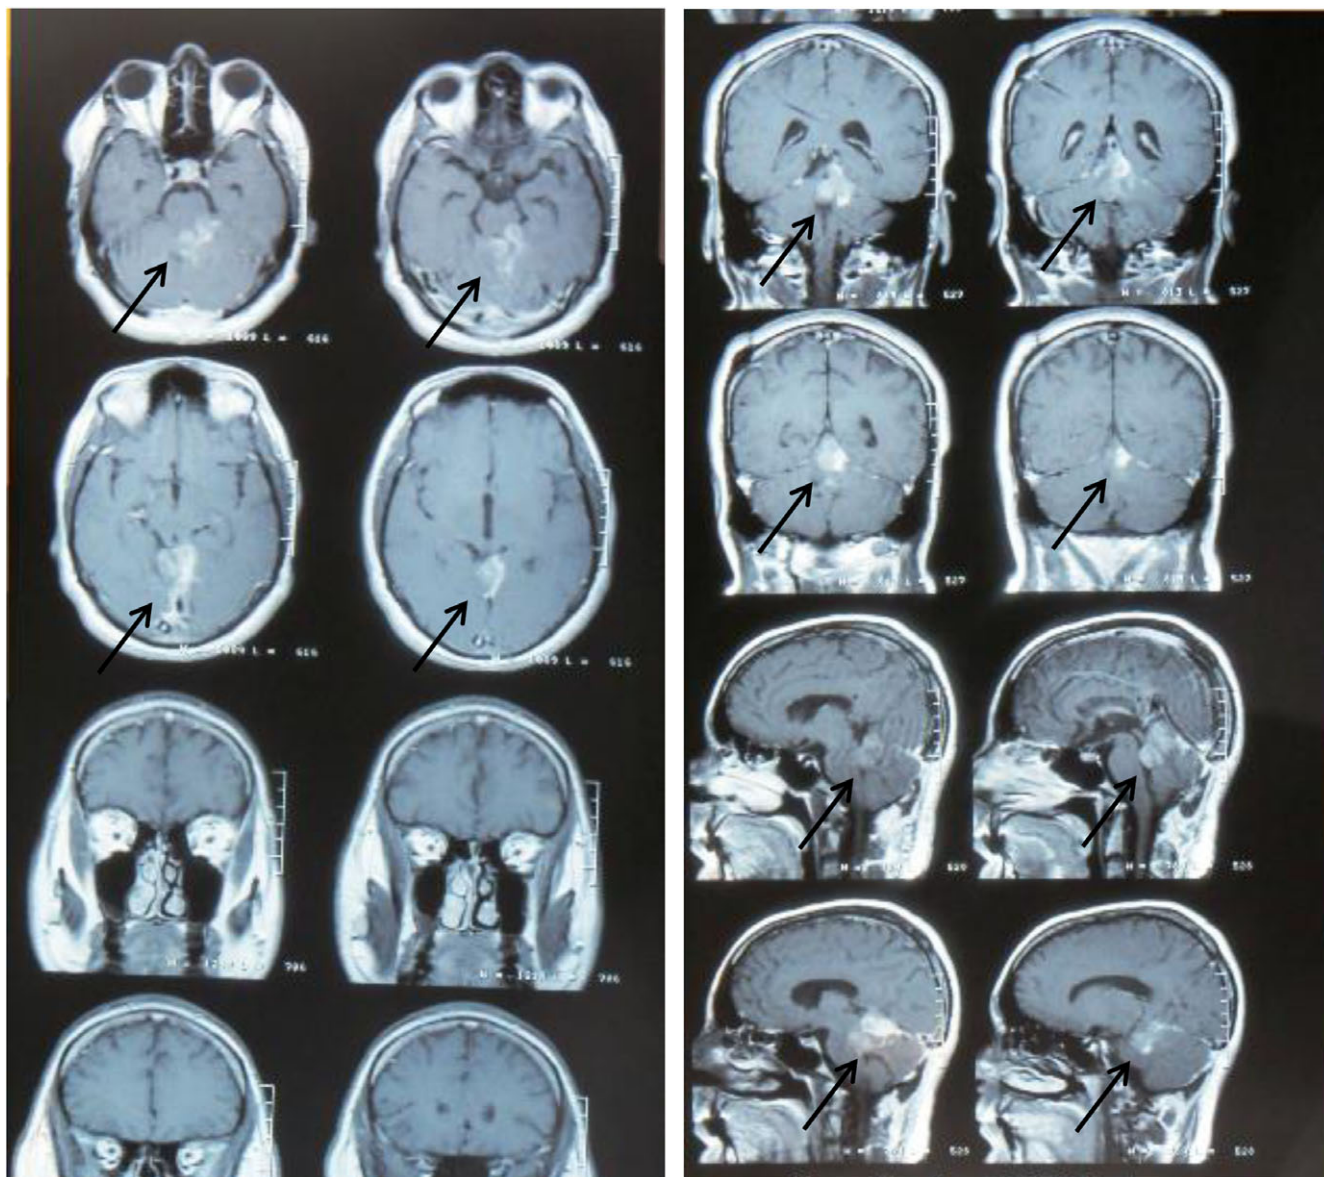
CT scan imaging results display 1.5x1.5x0.5 cm lesion resulted from tumour regrowth after treatment by dexamethasone. The tumour was clearly shown by arrows.
